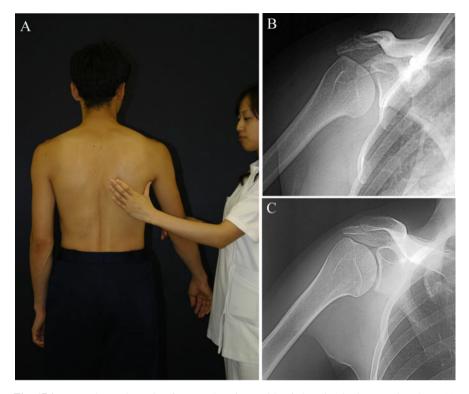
Manual muscle testing for arm elevation at 45° of elevation in the scapular plane. (a) Examiner holds the inferior angle of patient's scapula with her thumb and index finger when stabilizing the scapula during the testing. (b) X-ray image without examiner's assistance to hold scapula. (c) X-ray image with examiner's assist to hold scapula
